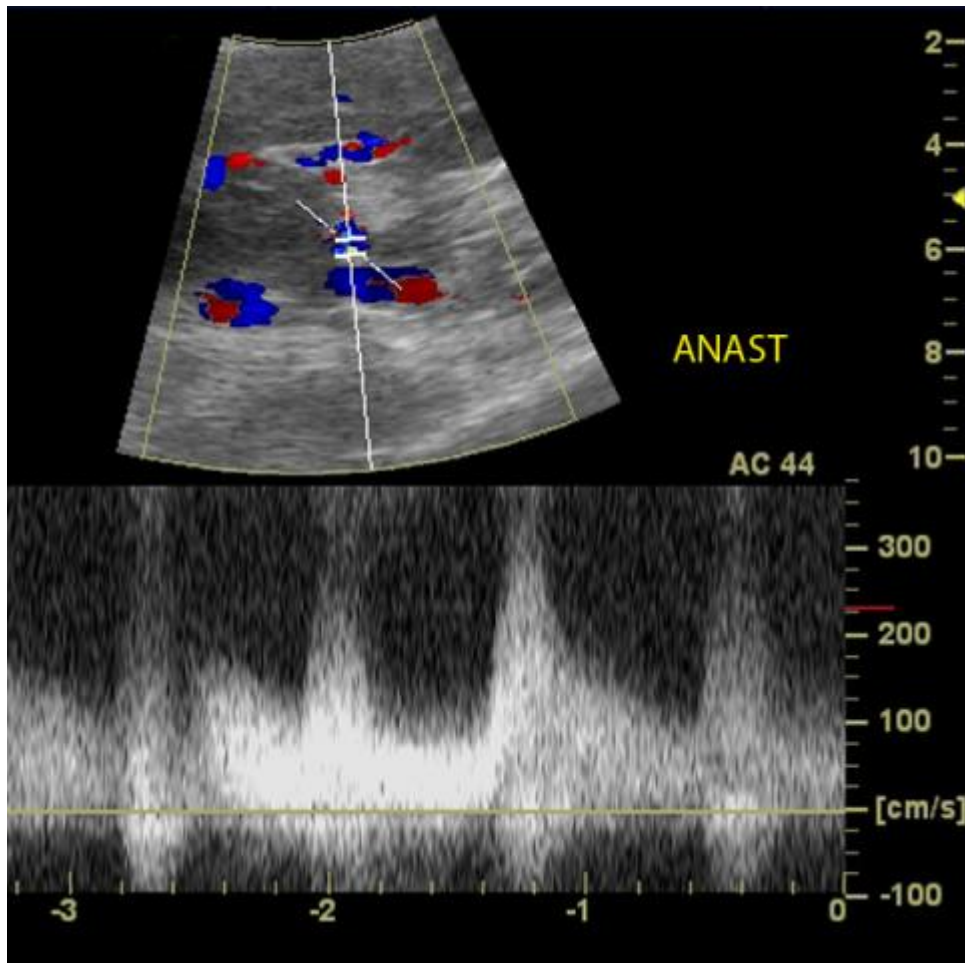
Arterial anastomotic stenosis. a) Spectral Doppler ultrasound image shows focally elevated velocity (measuring up to approximately 300 cm/s) at the arterial anastomosis.
